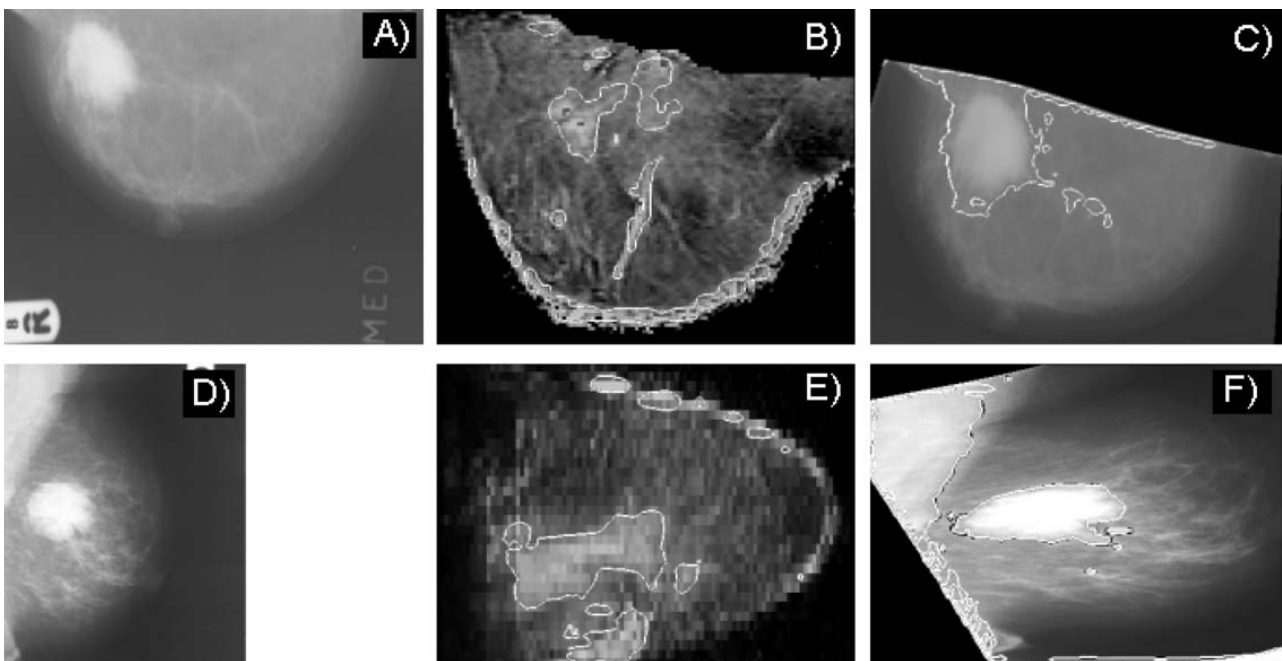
(A) and (D) are the original cranial-caudal and medial-lateral oblique mammograms, respectively. (B) and (E) show the segmented MRI functional projections. (C) and (F) depict the original mammograms registered to the MRI projections using the approach outlined in Figure 1.
